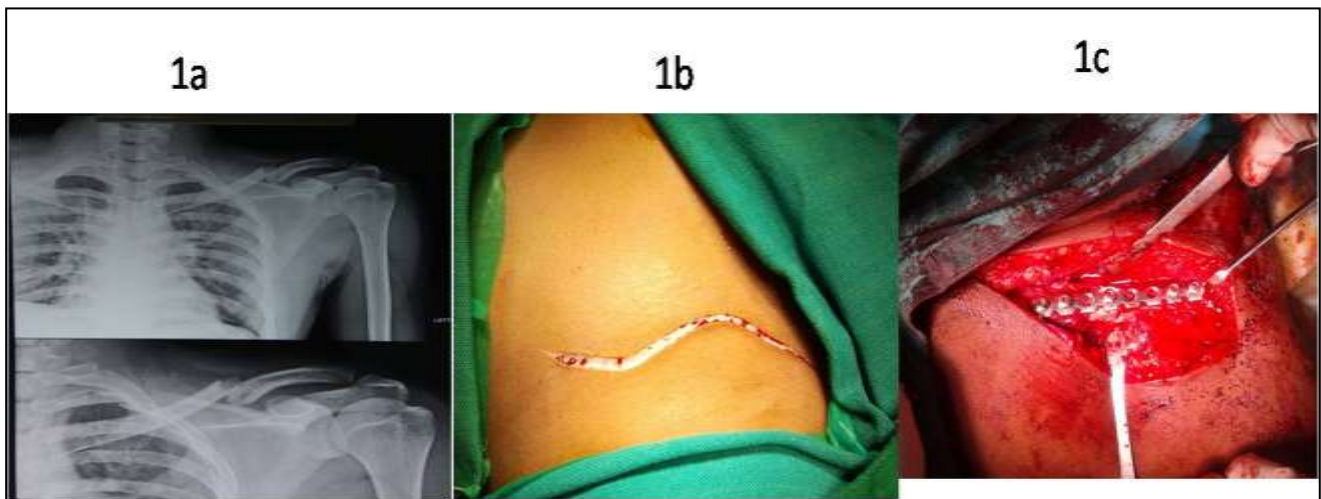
(a-c): Preoperative x-ray, skin incision for clavicle plating, plate fixation of clavicle fractures.
